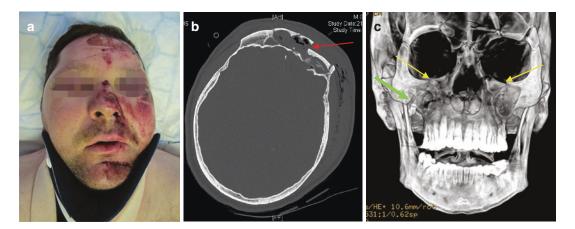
A 40-year-old patient sustained a fall with facial injuries (a). Bone windowed axial (b) and 3D reconstruction (c) CT images demonstrated a comminuted frontal bone fracture with involvement of the frontal sinus' anterior and posterior walls (red arrow). There were also
